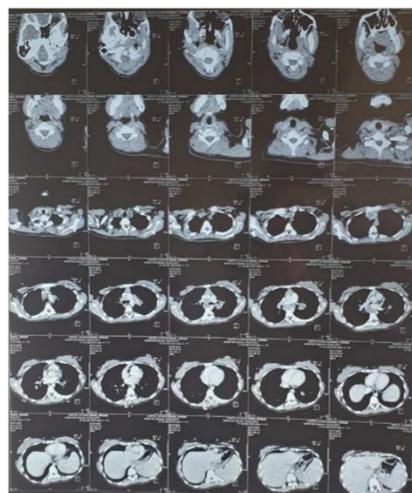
Cervical-thoracoabdominal axial CT scan.
